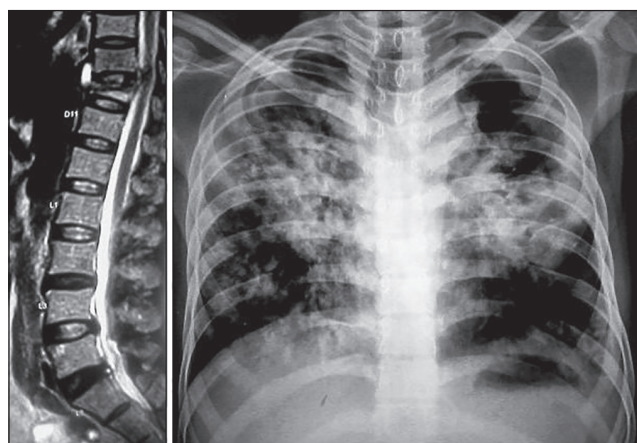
Magnetic resonance imaging of the spine showing thoracic D-9-10 Pott's spine with pulmonary tuberculosis
